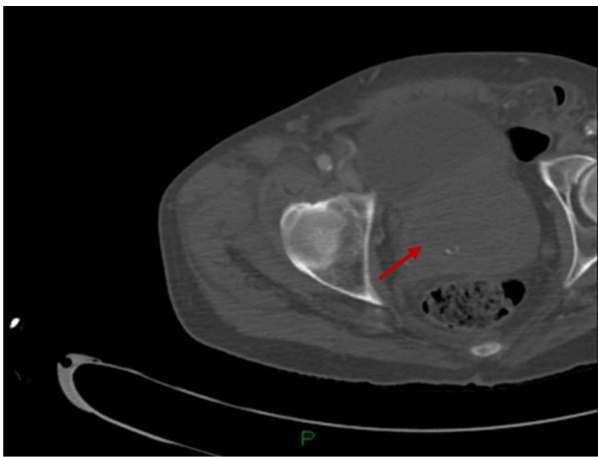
CT finding of an enlarged prostate measuring 7.0 cm \times 7.6 cm (shown by red arrow).
